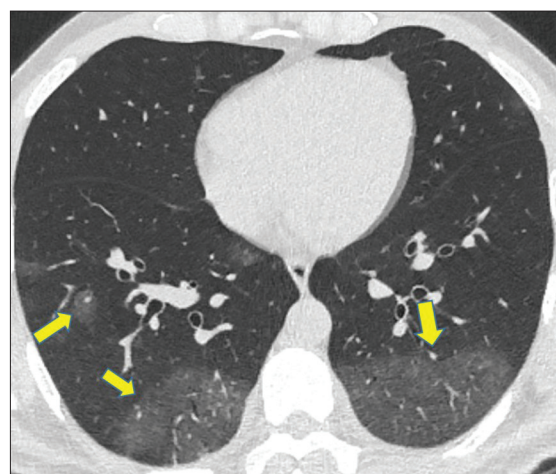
A 37-year-old male coronavirus disease 2019 patient presenting with fever and dry cough for 2 days. The computed tomography scan shows bilateral peripheral ground-glass opacities in the lower lobes
